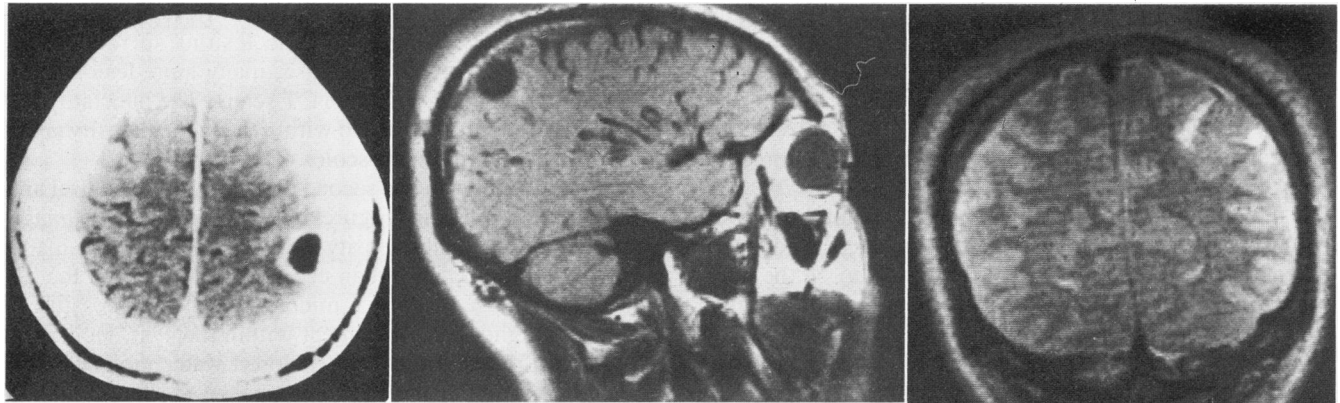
Patient 2. Left, A rim-enhancing, rounded lesion is seen in the left parietal convexity on this contrast-enhanced computed tomographic scan. Middle, Sagittal (repetition time [TR] 850 ms, echo-delay time [TE] 40 ms) and, right, coronal (TR 2,000 ms, TE 80 ms) spin-echo images of the cysticercal cyst show a long T1 and medium-length T2, with the surrounding high intensity on the coronal scan probably representing edema. Effacement of the surrounding sulci is better shown on the T1-weighted image (middle), while effacement of the normal surrounding white matter shows better on the T2-weighted coronal scan (right).
